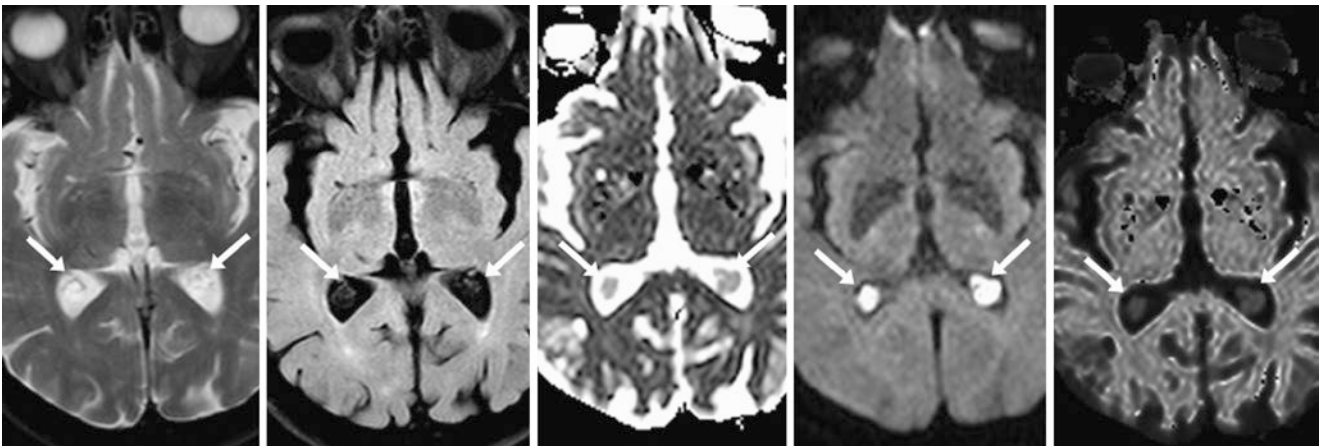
A 79 year old with bilateral CPXGs (arrows). A 1.5 T MRI, axial T2WI (left), FLAIR (left middle), ADC (middle), DWI (right of middle), and “exponential” DWI (right, removes the T2 contribution from the DWI) show that the CPXGs suppress on FLAIR but have a
